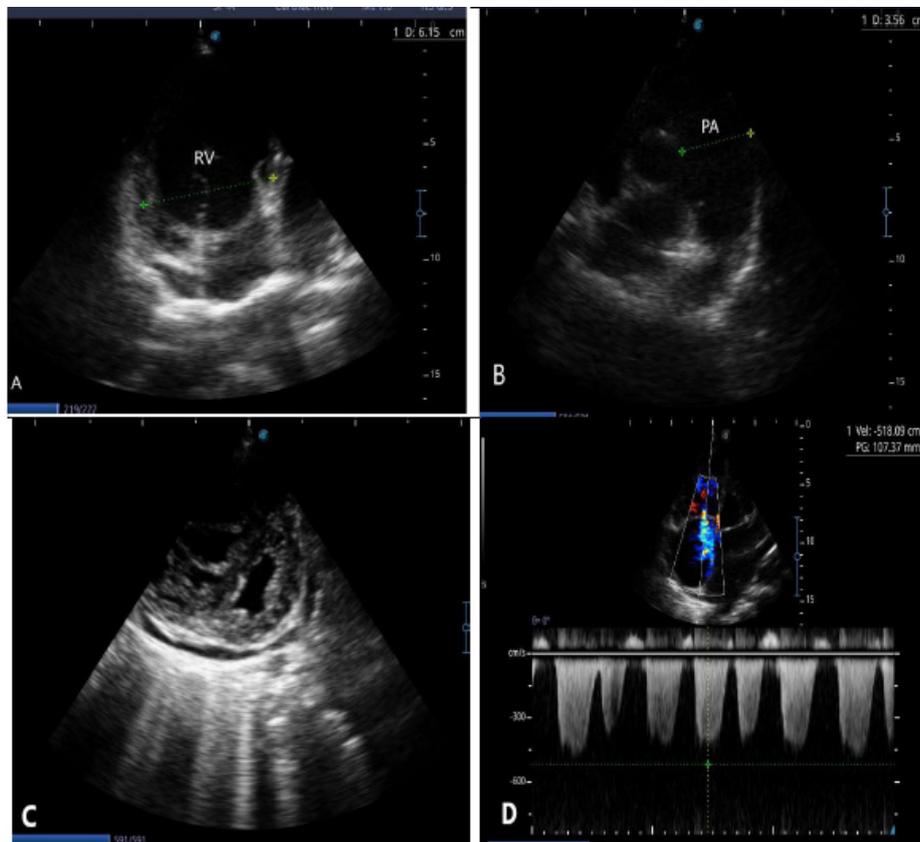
Doppler echocardiography in 4-chamber short axis view shows: A) Severe right ventricular enlargement; B) Dilated main pulmonary artery and its branches; C) D-shaped septum; D) Severe tricuspid regurgitation with PG:107 mm Hg.
